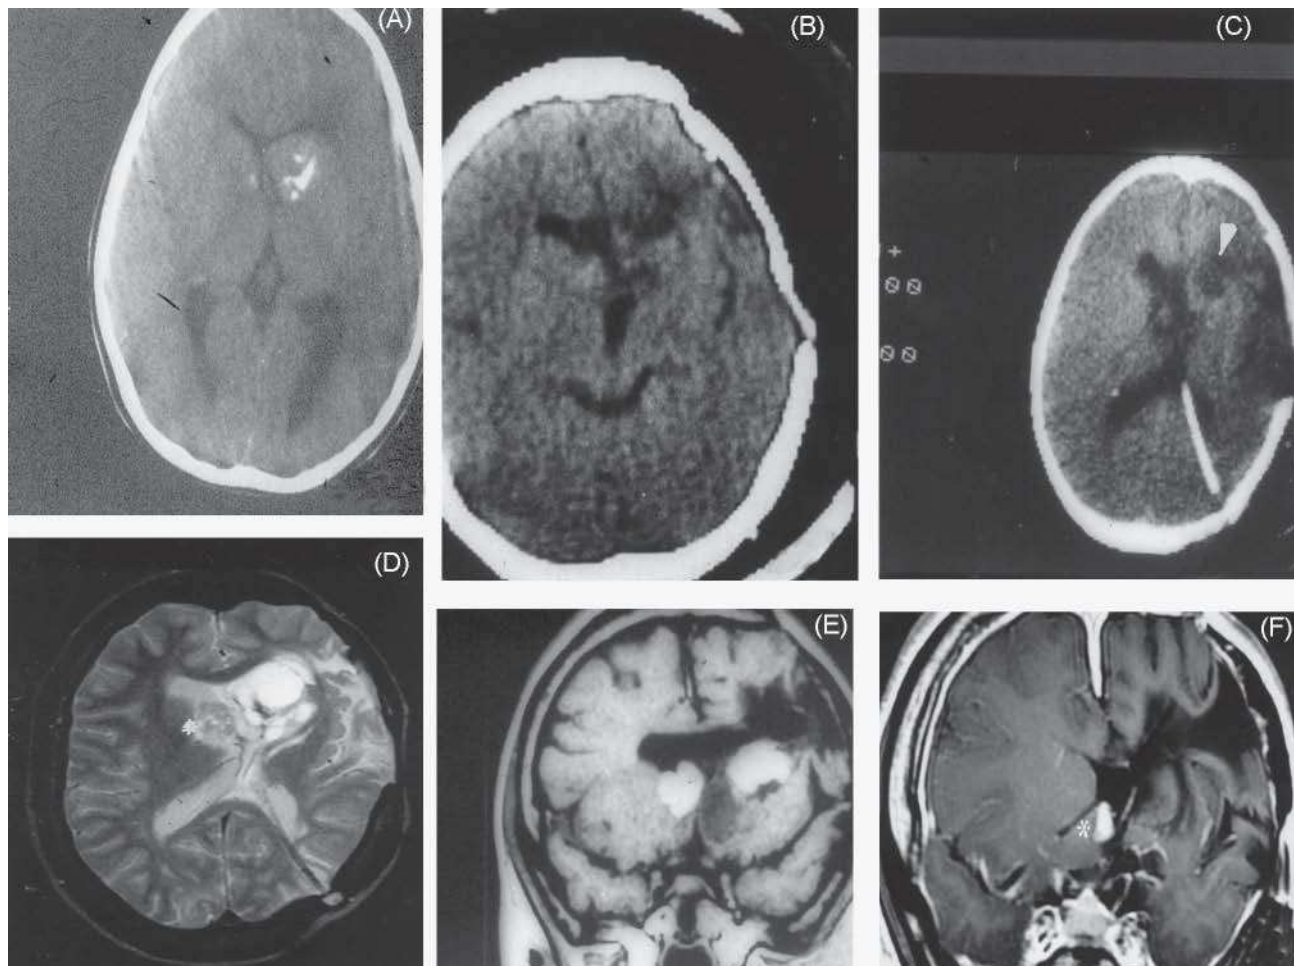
Case 1. A: computed tomography (CT) scan in axial projection at 5 years of age. Tumour with intratumoral calcification in the left lateral ventricle. B and C: CT scans of the same patient in axial projection 11 months later, showing the reproduction of the tumour that had been partially removed (arrowhead). D: Magnetic resonance imaging (MRI) in T2 and gadolinium-enhanced at 23 years of age. Tumour recurrence presenting tension and multi lobular appearance. Strong bulging of the tumour footprint in the head of the right caudate nucleus (asterisk). E: coronal section of gadolinium MRI at age 25 showing a third tumour recurrence that reaches the solid and cystic parts on the left side. Large size of the solid tumour area also on the right side. F: coronal section of gadolinium MRI at age 26, after the last tumour resection. There is no trace of the tumour in the left hemisphere, only a small remnant in the right side (asterisk). Large postoperative ventriculo-cortical sample in the left hemisphere.
